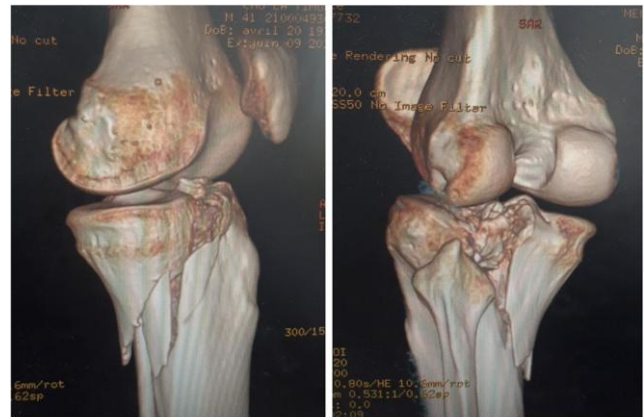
Clinical case: 40-year-old patient. Closed Schatzker 6 TPF. Pre-operative CT SCAN: 3D reconstructions
